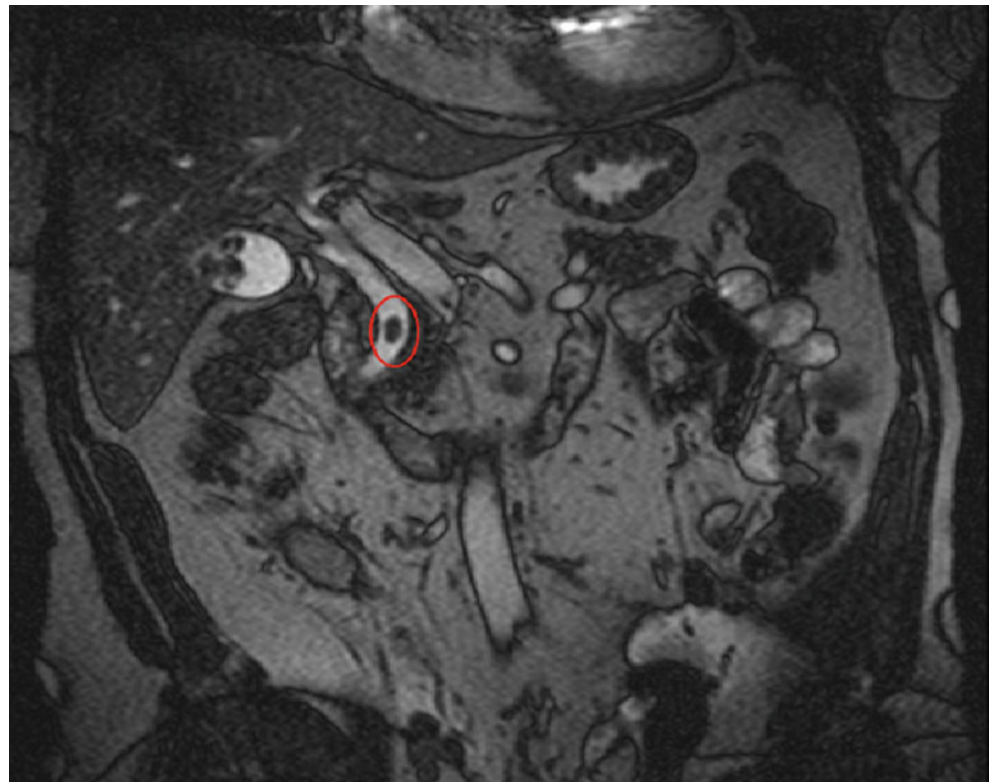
T2-weighted MRCP showing a large stone in the common bile duct (*highlighted oval*)
